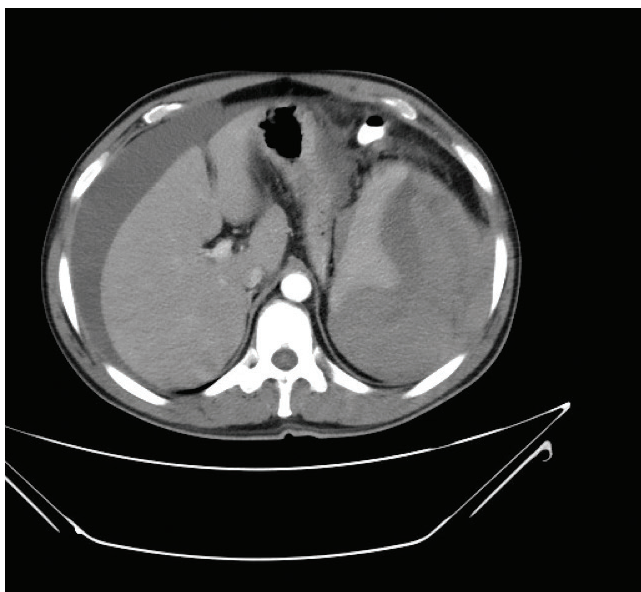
CT image of spontaneous splenic rupture.
